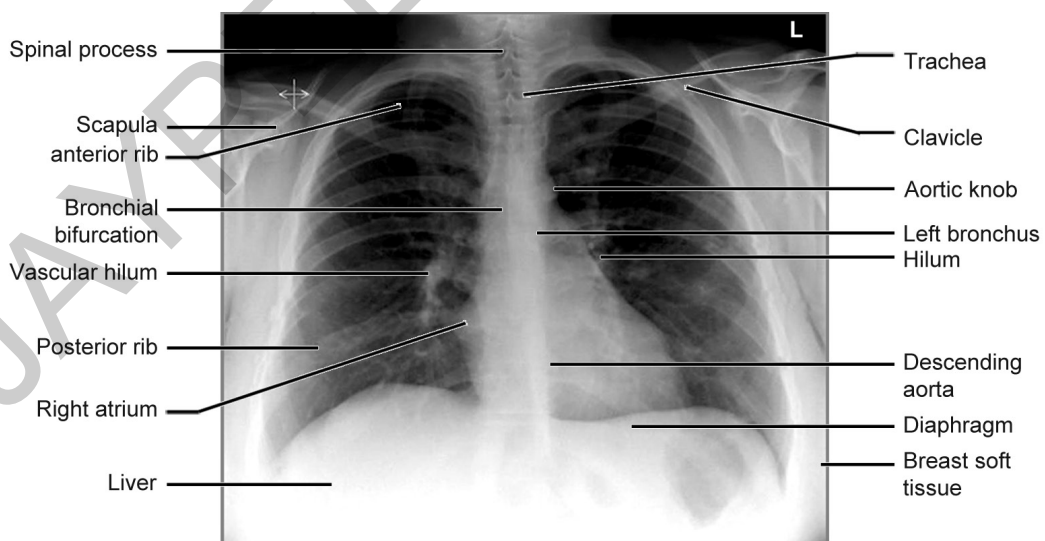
Normal chest X-ray.
